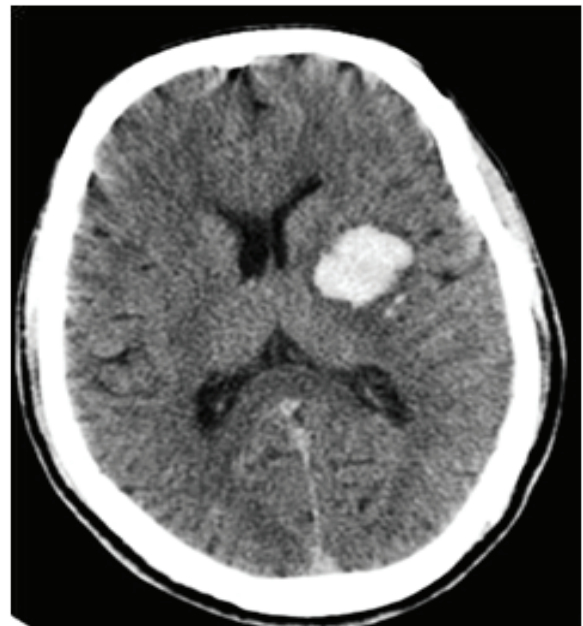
CT – Brain revealing hemorrhage in left lentiform nucleus and internal capsule
